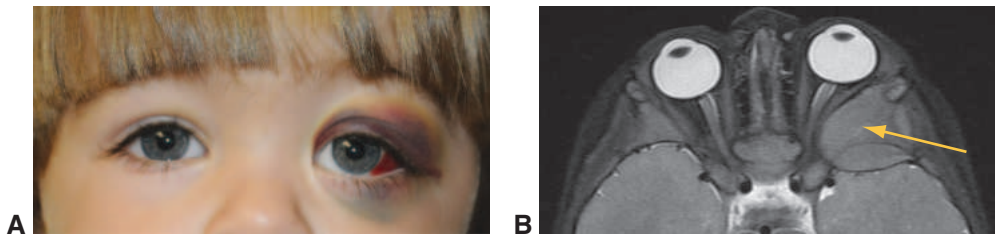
Metastatic neuroblastoma. A, Child with metastatic left orbital neuroblastoma. B, T2-weighted MRI shows a large infiltrating lesion of the left sphenoid wing extending into the orbital soft tissues and the temporal fossa (arrow). (Courtesy of Bobby S. Korn, MD, PhD.)
